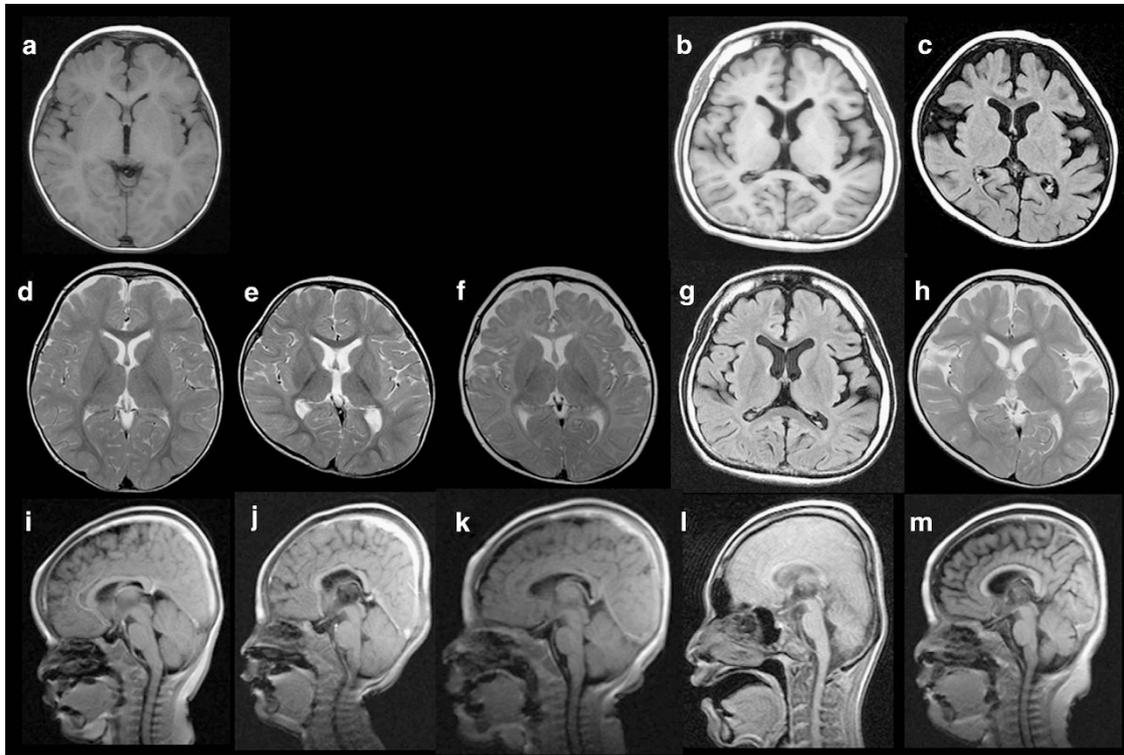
Brain magnetic resonance imaging (MRI) results. (a,b) T1-weighted axial images; (c,g) fluid attenuated IR (FLAIR) axial images; (d–f,h) T2-weighted axial images; (i–m) T1-weighted sagittal images. No definitive abnormality was observed in patient 1 (a,d,i), patient 2 (e,j), or patient 3 (f,k). Mild volume loss was observed in patient 4 (b,g,l). Mildly reduced volume was noted, predominantly in the frontal region of patient 5 (c,h,m).
